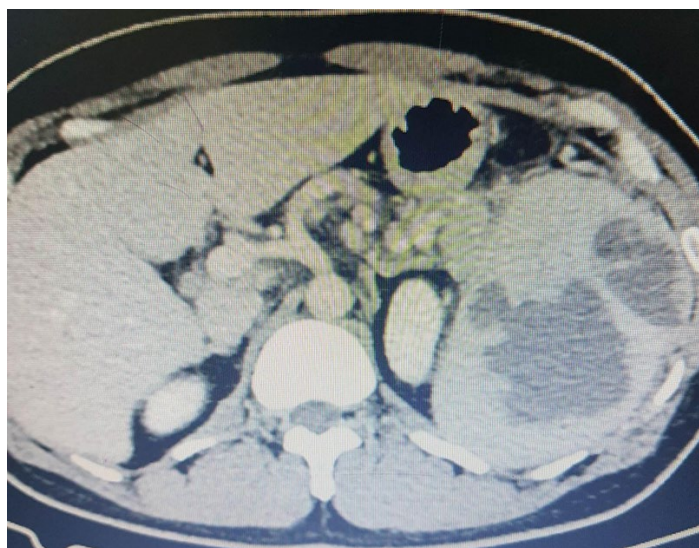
CT scan of the whole abdomen with contrast: Splenomegaly with rim enhancing near fluid attenuating lesions in the mid to inferior pole, consider abscess formations or necrotic neoplasms
